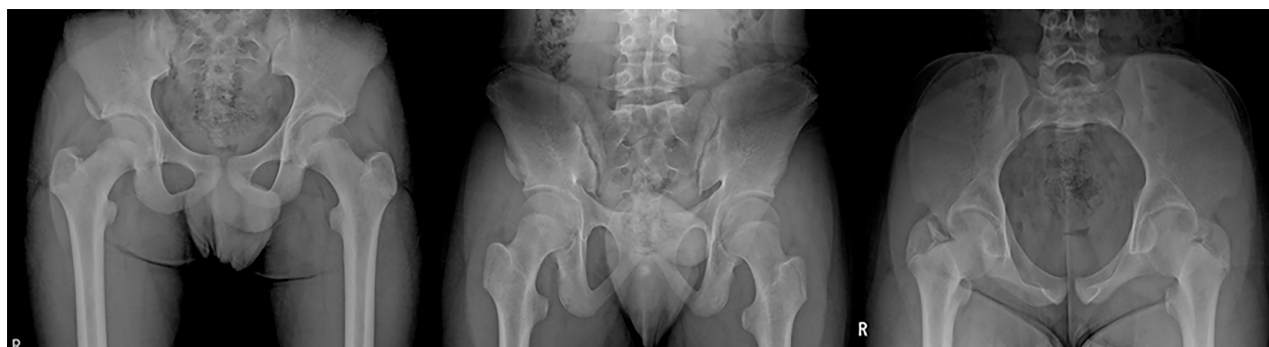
X-ray taken after the initial trauma showing a right avulsion fracture of the apophysis of the anterior inferior iliac spine.
